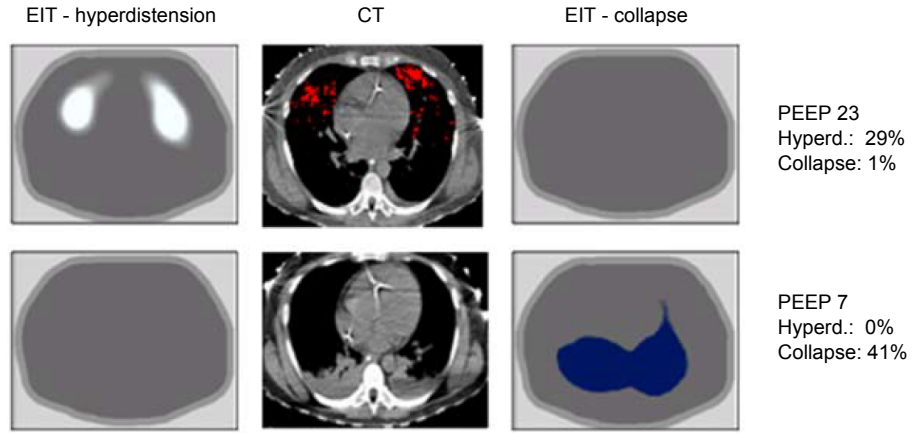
Visualization of hyperdistended (left column) and collapsed (right column) lung regions for two different *PEEP* settings in a patient with pneumonia. For comparison, corresponding CT images are presented in the middle column. Adopted from [6].
